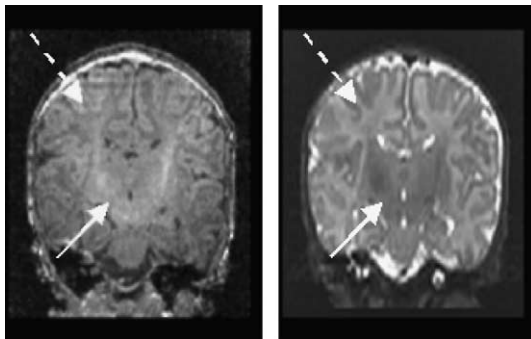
MR images of a newborn brain (subject 0096, coronal view). Left: T1w image, right: T2w image. The arrows show the white matter structure. The arrow with the solid line indicates myelinated white matter, the arrow with the dashed line indicates non-myelinated white matter. Early myelination in white matter is shown as bright regions in the T1w image and dark regions in the T2w image.
